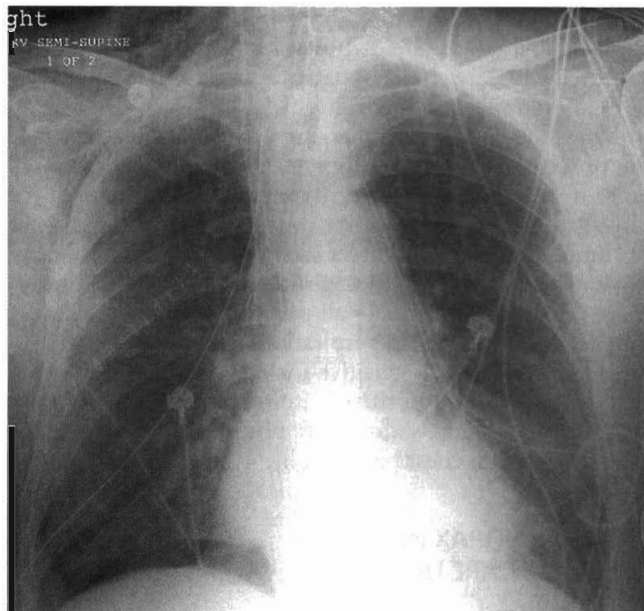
A semi-upright anteroposterior chest radiograph shows subcutaneous air and a hyperlucency along the right hemidiaphragm consistent with a basilar pneumothorax.
